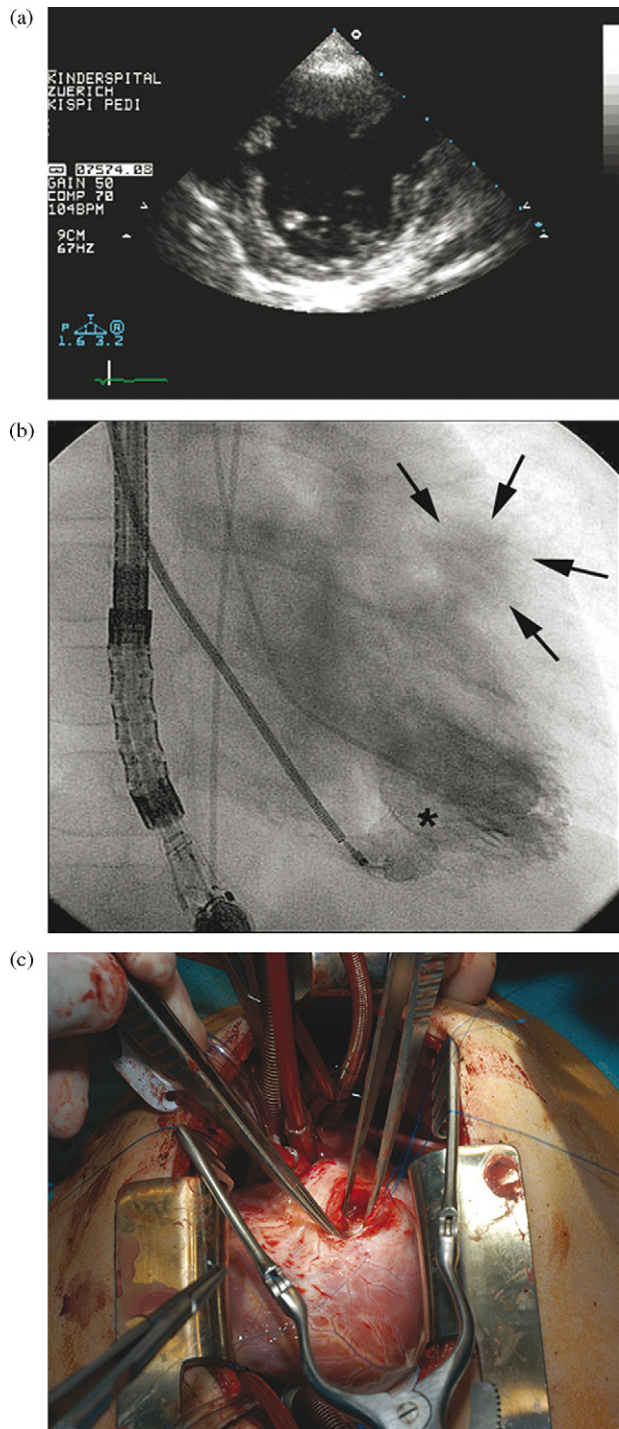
(a) Parasternal short axis view of 2D-transthoracic echocardiogram revealing the VSD (\*) and the pseudoaneurysm of the LV free wall (arrows). (b) Interventional catheter image showing the placement of the Amplatzer VSD occluder device with an already opened left ventricular disc (\*). The right-sided disc is still mounted on the catheter. (Arrows: pseudoaneurysm of the LV free wall). (c) Intraoperative situs demonstrating the opened pseudoaneurysm cavity prior to layered closure with a running suture.
